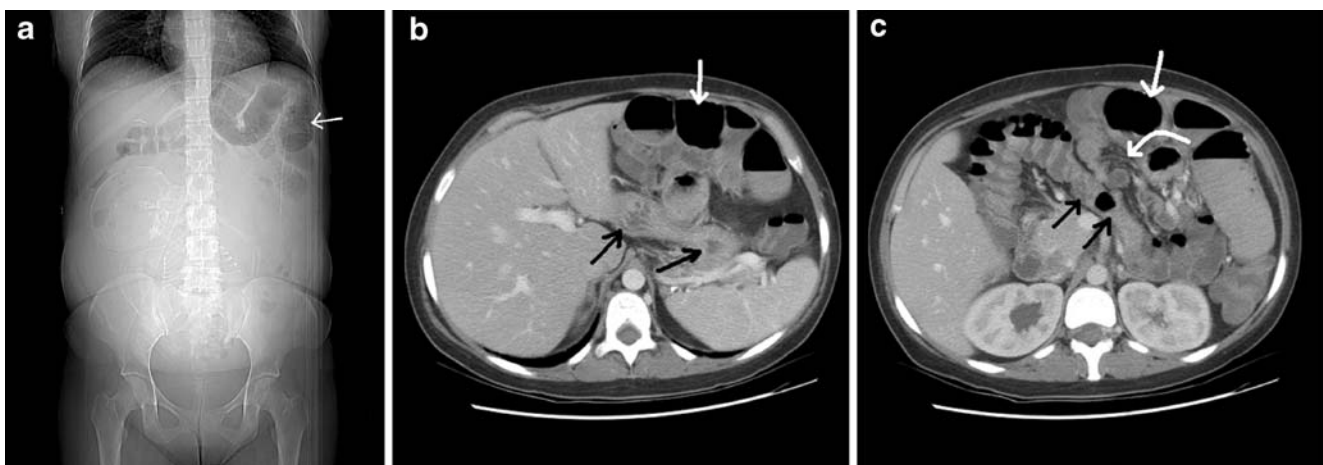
a CT scan scout shows a closed-loop obstruction with a cluster of small-bowel loops in the left upper quadrant (*white arrow*). b Transverse CT scan shows a closed-loop obstruction with a dilated cluster of small-bowel loops adjacent to the anterior abdominal wall (*white arrow*) and the remnant stomach displaced posteriorly (*black arrow*). c Transverse
